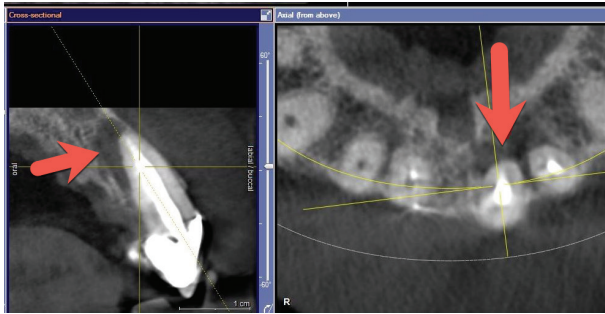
Periapical pathology
